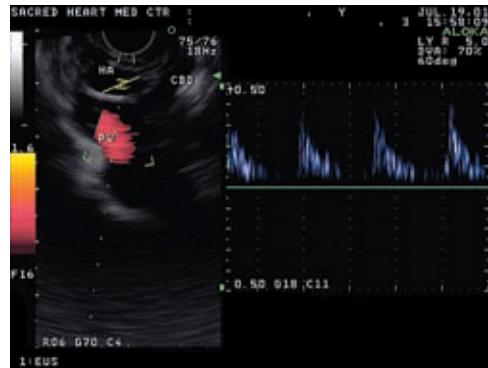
An EUS Doppler study revealed crossing of the common hepatic by the right hepatic artery.
